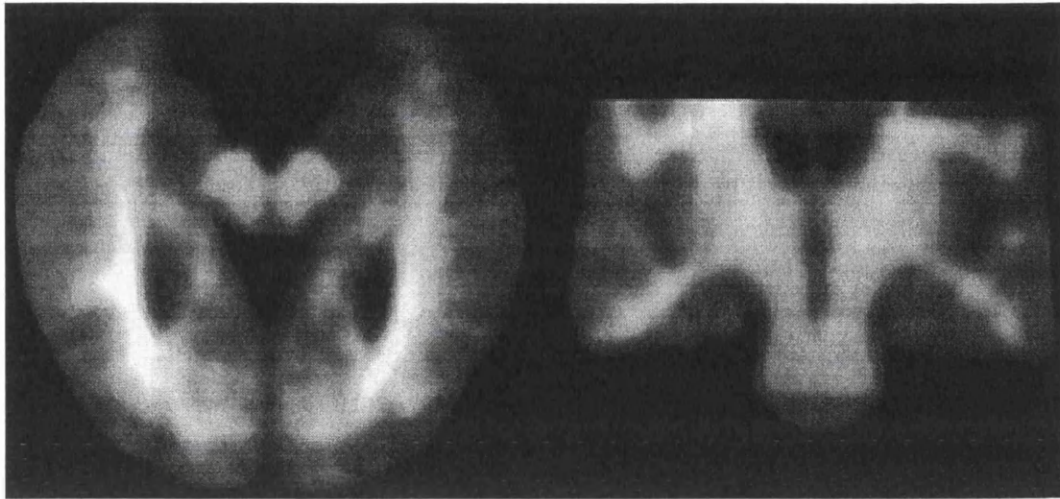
Normalised MRI template
